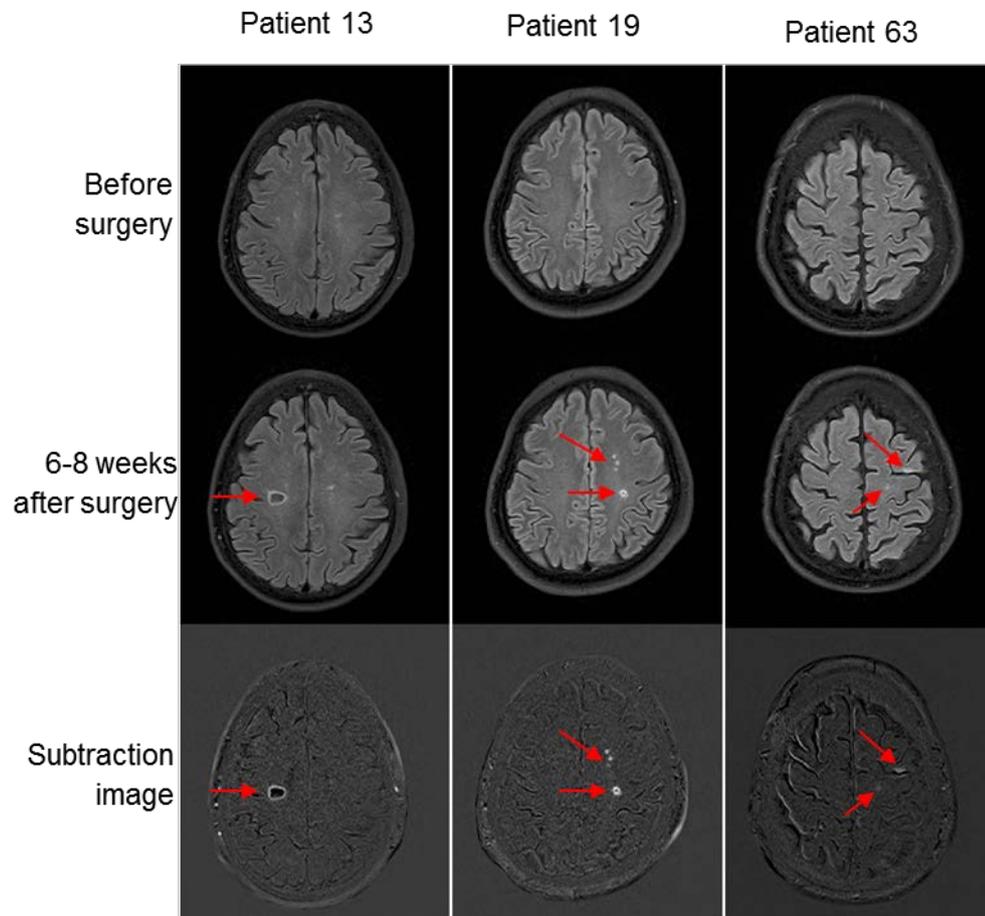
Comparison of FLAIR MR images obtained 1-2 weeks before and 6-8 weeks after cardiac surgery. Registration and subtraction of MRI data were performed using 'in house' software to confidently distinguish new ischaemic lesions from pre-existing infarcts and provide an estimate of the position and volume of new lesions.
